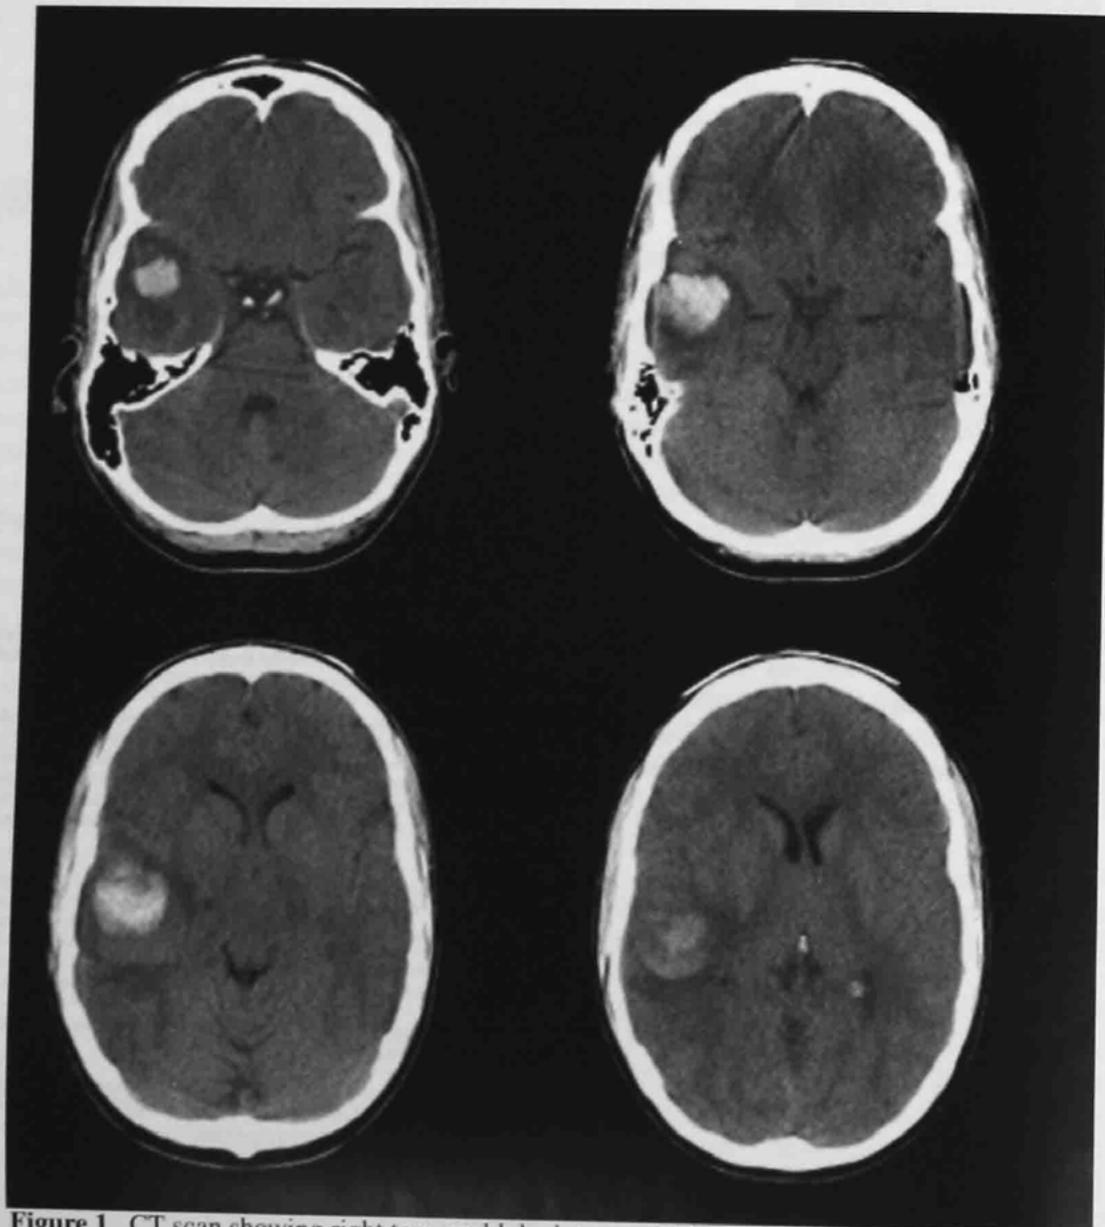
CT scan showing right temporal lobe intracranial hemorrhage with minimal shift and some edema.
